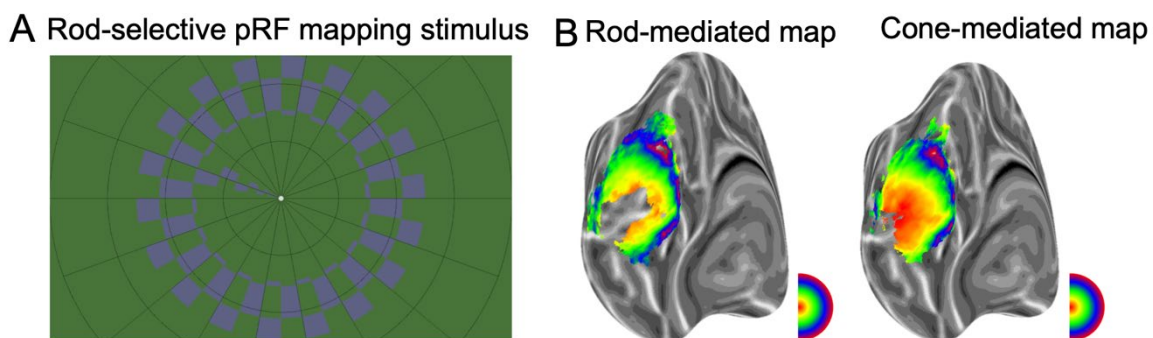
A) Rod-selective pRF mapping stimulus shown in the MRI scanner. Participants detected target dimming events at fixation. B) Left: rod-mediated pRF map, obtained with stimulus in (A) averaged across 26 normally sighted control participants. Right: Cone-mediated pRF map obtained with stimulus in Main Figure 1C, averaged across 28 normally sighted control participants. Loss of signal around the fovea in the rod-mediated map compared to the cone-mediated map (areas coded red), suggests cone responses around the fovea were successfully reduced by the rod-selective stimulus. Both maps are generated by co-registering every control participant's individual cortical surface to a common cortical surface (the fsaverage) using cortex-based alignment as implemented in Freesurfer. Functional pRF mapping data was sampled to this common cortical space, thresholded at $R^2 > 0.05$, and averaged across participants. In areas not colour-coded by eccentricity, none of the control participants had a pRF fit that survived the statistical threshold.
